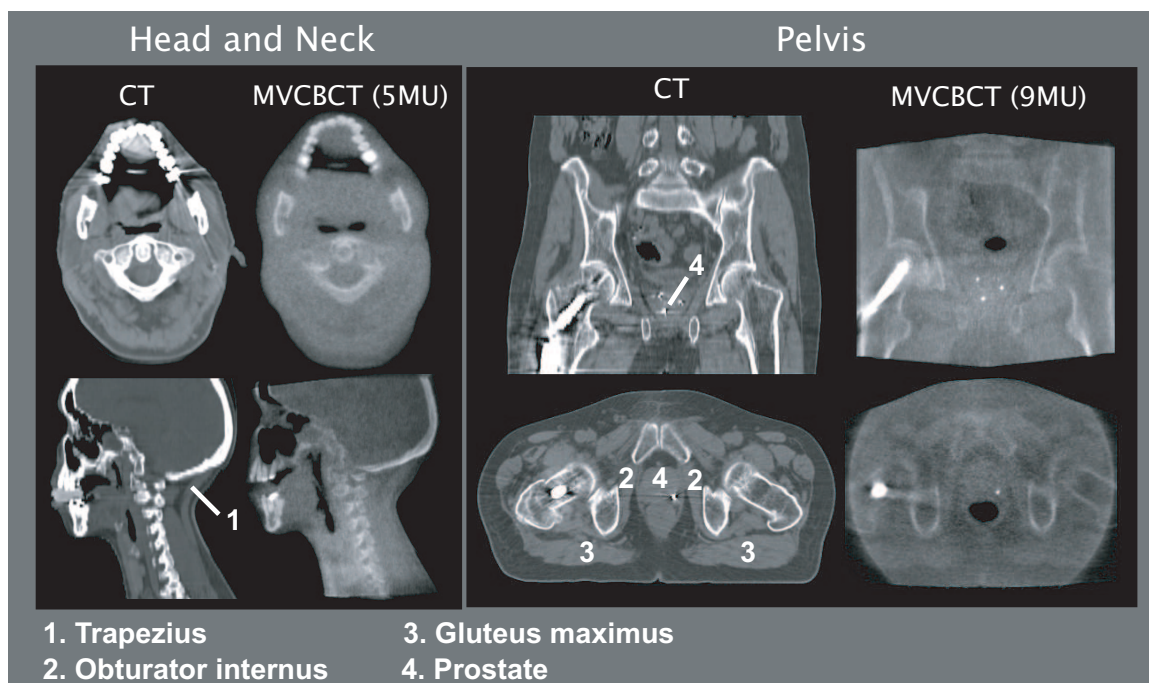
Typical MVCBCT images for head and neck (5MU) and prostate (9 MU) patients compared to conventional CT. The image quality of MVCBCT is sufficient to perform a 3D alignment based on bony anatomy and soft tissue. Several muscles and the prostate can be identified on both the CT and MVCBCT images. CT and MVCBCT images are not displayed with the same window and level.
